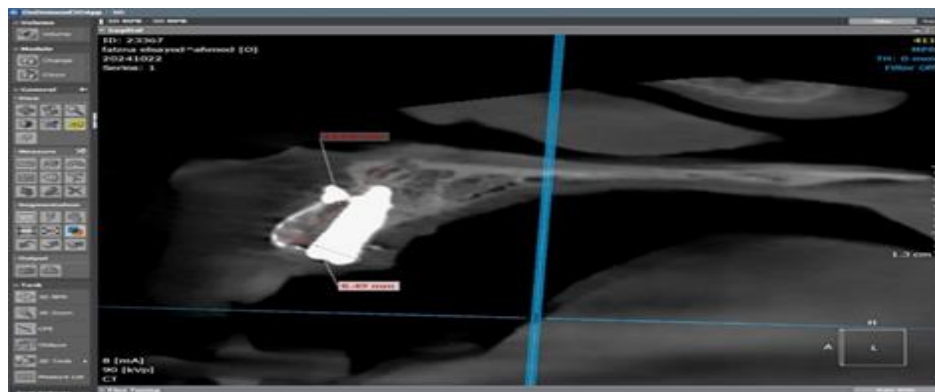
6 months Postoperative CBCT measurement for both width and height for case number 3, width: 8.49mm, height: 14.69mm
